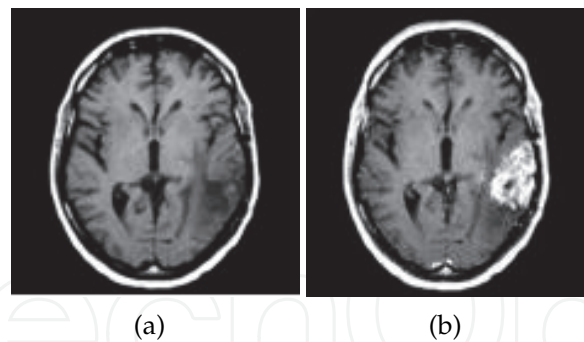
Effects of contrast agent. (a): T1-weighted image, (b) T1-weighted image after contrast injection
